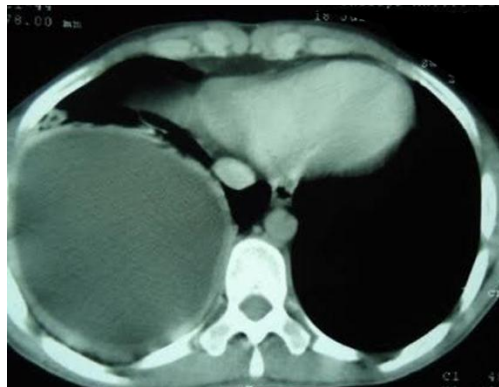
Chest CT scan A large round right basal pulmonary image
